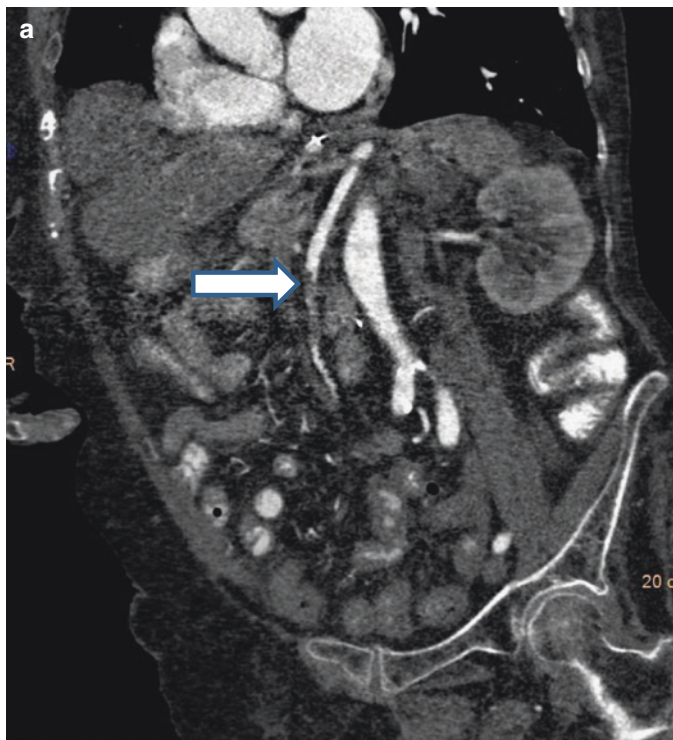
This patient, who had atrial fibrillation and was not receiving anticoagulant therapy, had an acute onset of severe abdominal pain. These selected images are from a CT scan of a patient with acute mesenteric ischemia secondary to occluded SMA from an embolic source (*arrow, a*). Also CT showed ischemic ileum and right colon (*b*); portal venous gas was found (*c*). 3D reconstruction clearly demonstrates distal occlusion of SMA (*d*). At laparotomy, the distal ileum and ascending colon were found to be ischemic and were resected; an SMA thrombectomy (*e*) and vein patch angioplasty was performed
